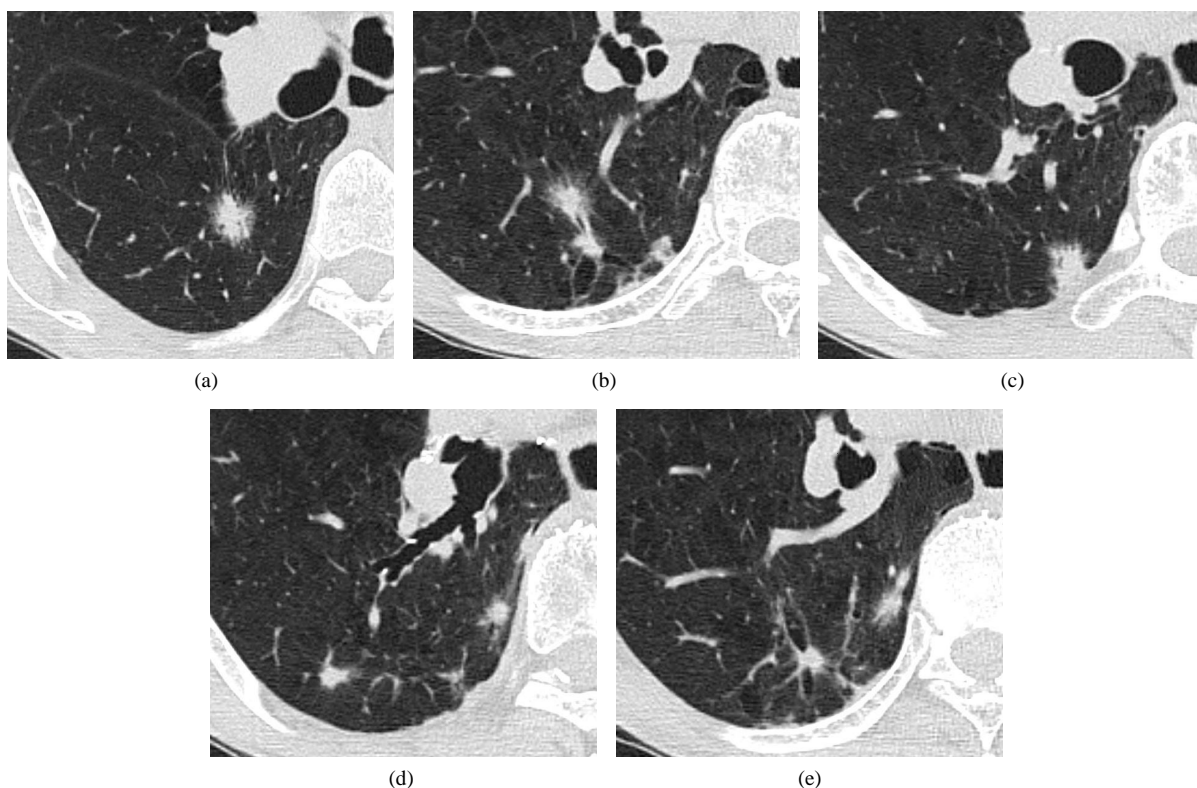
Chest CT in July 2011: (a) One of the two GGO lesions found in 2008 had increased in diameter from 7 mm to 17 mm, and containing an internal solid component; (b) The other GGO found in 2008, also showing a solid component, had increased in diameter from 6 mm to 13 mm; (c)-(e) Multiple lesions are visualized in S6 of the right lower lobe.
